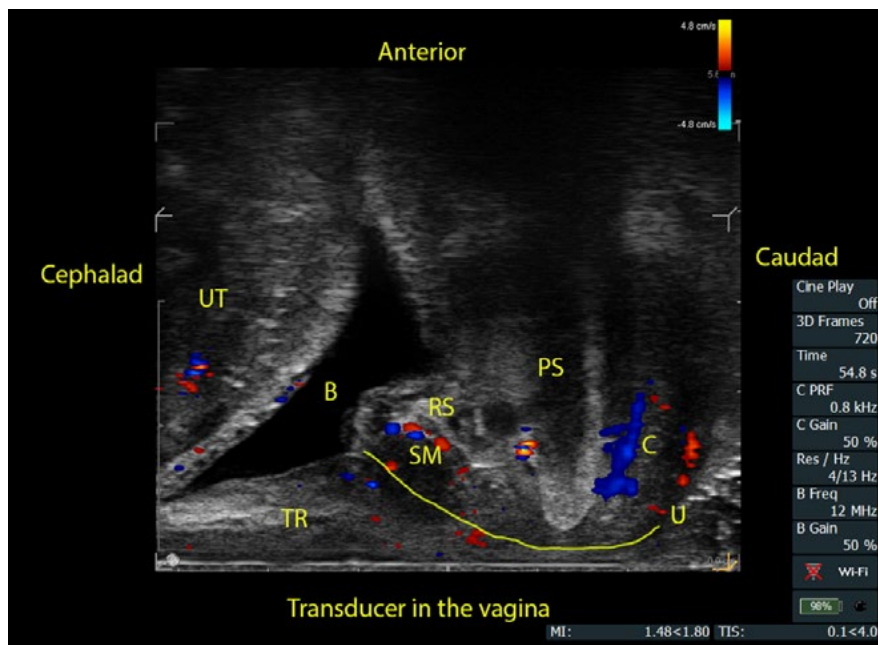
Anterior compartment with doppler flow view of the urethra and the bladder. B= bladder, C= Clitoris, PS= pubic symphysis, RS= rhabdomyosphincter, SM=Smooth muscle, TR= trigone, U=Urethra delineated by the yellow line, UT=Uterus (anterior edge of the uterus is seen cephalad to the bladder).
